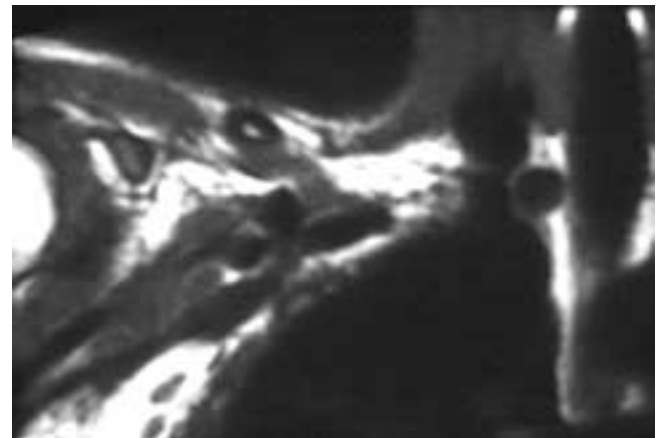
Status after a traction injury of the right shoulder. T1-weighted coronal image shows nodularity and thickening of the brachial plexus consistent with ganglion formation.
